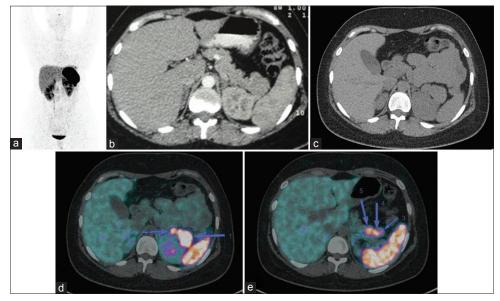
(a) ⁶⁸Ga-DOTA-NOC PET/CT maximum intensity projection image showing physiological distribution and no overt focus of abnormal localization. (b) Transaxial contrast-enhanced computed tomography showing bulky tail of pancreas but no definite enhancing lesion. (c) Transaxial noncontrast computed tomography showing bulky tail of pancreas but no definite lesion. (d) ⁶⁸Ga-DOTA-NOC PET/CT transaxial slice at the level of pancreas showing intense uptake of tracer in the tail with a discrete lesion proximal to it - ?node. (e) ⁶⁸Ga-DOTA-NOC PET/CT transaxial slice at the level of pancreas showing two other distinct foci of intense uptake corresponding to rounded nodular lesions near the primary - consistent with peripancreatic nodes
